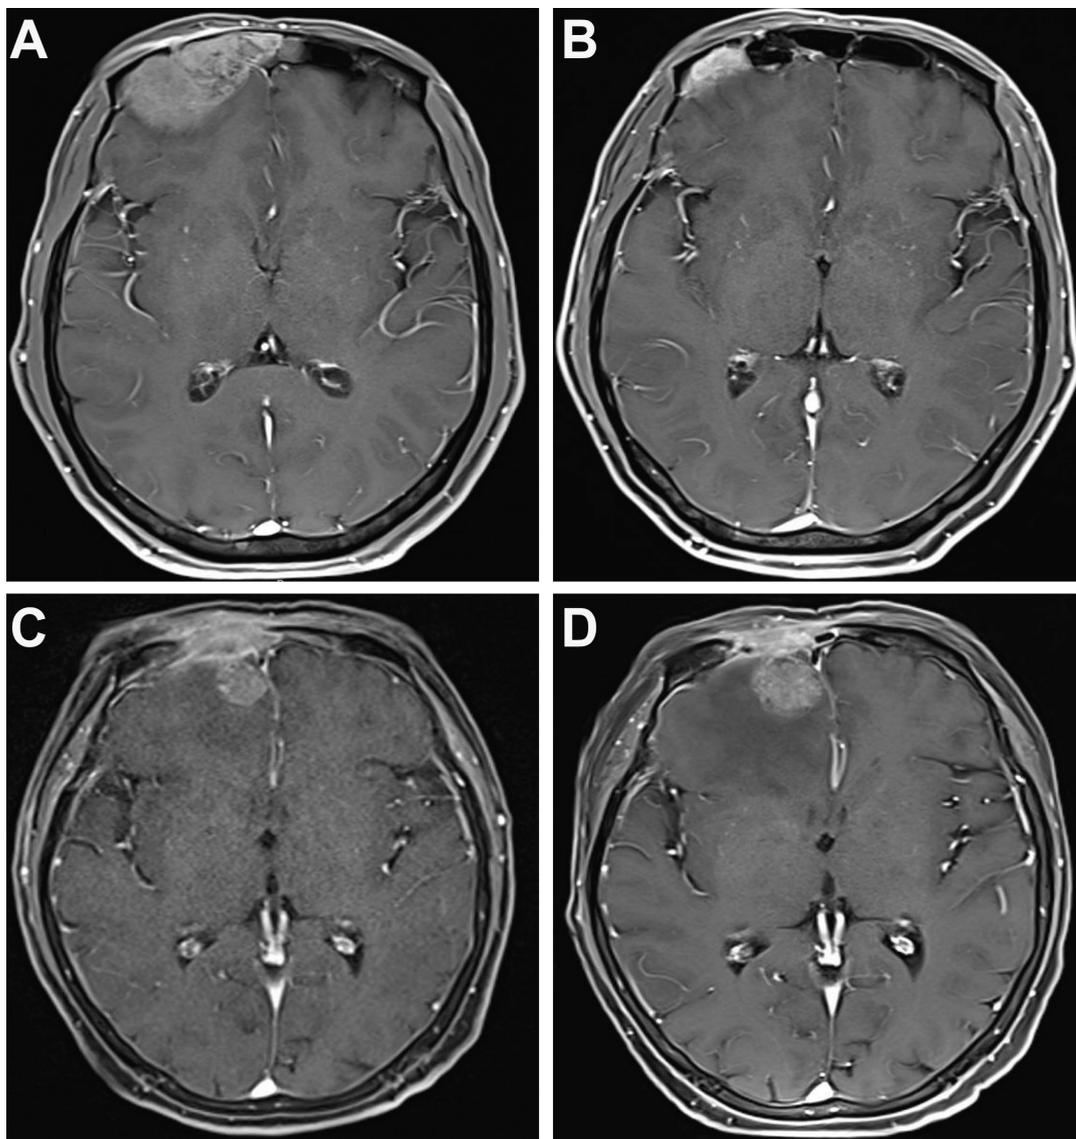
Contrast-enhanced T1-weighted MRI scan demonstrated a neoplasm with intense enhancement: A, B) partial response after induction chemotherapy; C, D) progressed disease after induction chemotherapy.
